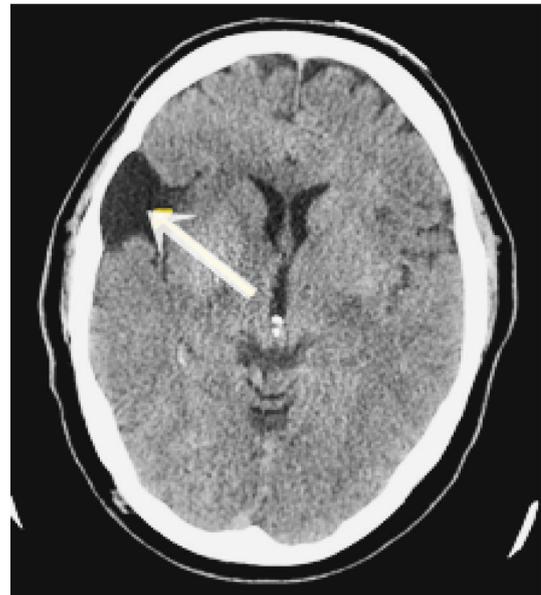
Case 1 CT scan demonstrates cyst and edema in the right frontal lobe.
